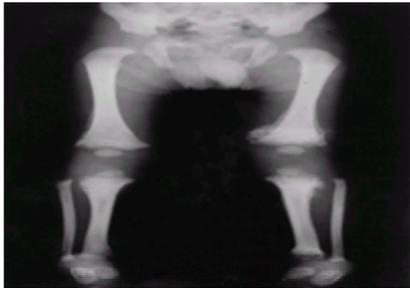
Child abuse in a 4-month-old baby refusing to move his left limb. Radiograph shows bilateral metaphyseal corner fractures at different stages of healing.
